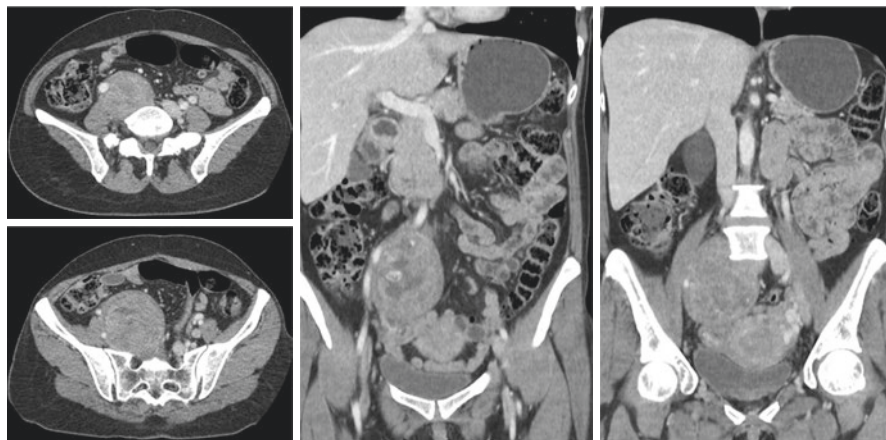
A 53-year-old female patient complaining of abdominal pain with radiation to the posterior region of the right lower limb. The CT shows a solid retroperitoneal mass with wide contact to L5 and S1 vertebral bodies. The lesion compresses and displaces the right iliac vessels. An image-guided biopsy was performed and the diagnosis of schwannoma was confirmed
